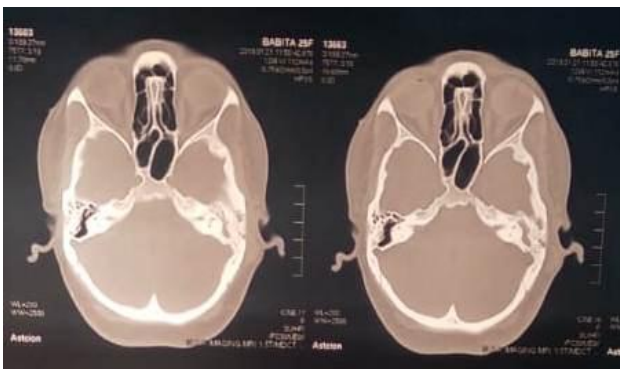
High-resolution computed tomography temporal bone axial view showing soft tissue density.
